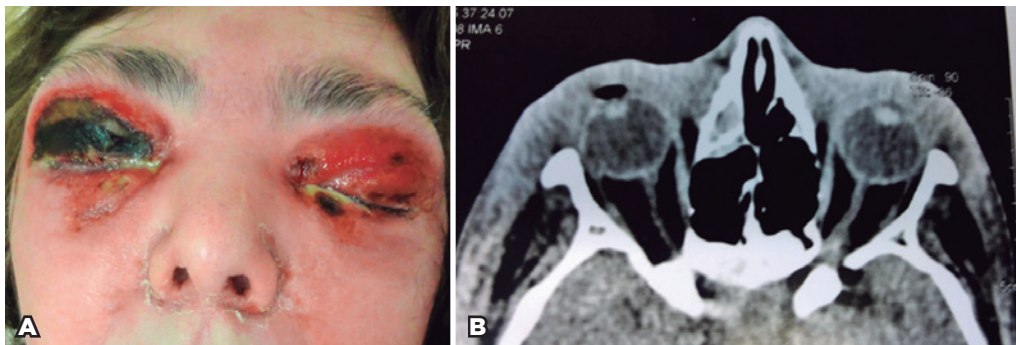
A) Clinical presentation: bilateral eyelid edema and full facial redness; B) Subcutaneous swelling identified in computed tomography scan.
